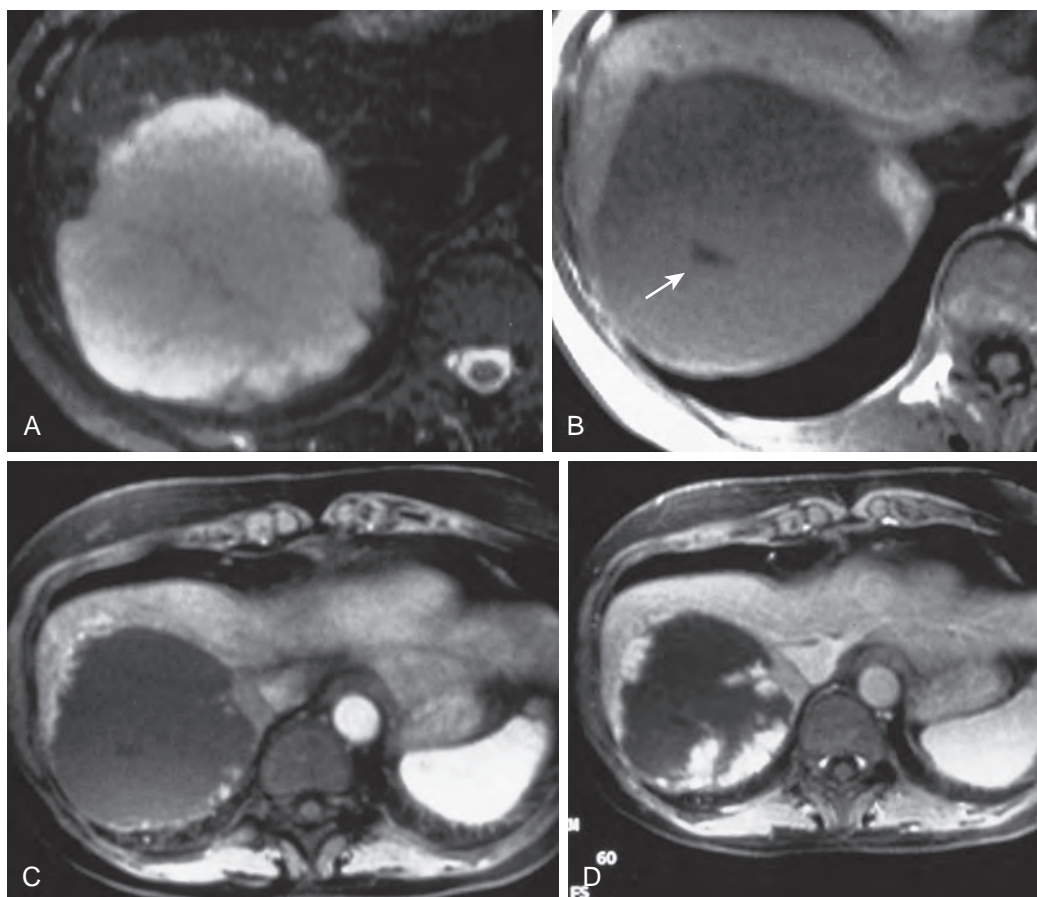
Hepatic hemangioma: MRI findings. A. Nonenhanced T2-weighted MR image shows a large hyperintense hepatic mass. B. Nonenhanced T1-weighted image shows low signal intensity. There is a central scar (arrow) that is often seen in large hemangiomas. C and D. Gadolinium enhancement demonstrates the characteristic peripheral nodular enhancement pattern that shows centripetal progression.
